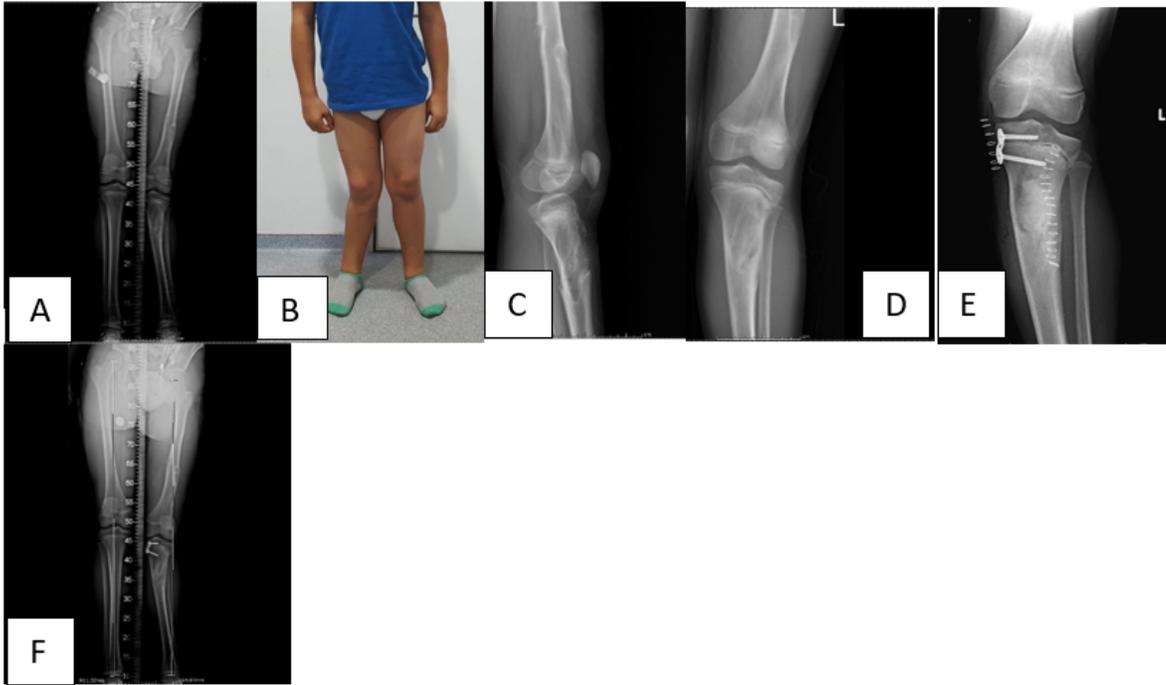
(A) Deformity and limb length discrepancy due to multiple enchondromatosis. (B) Clinical deformity. (C) Lateral x-ray. (D) AP x-ray. (E) Curettage and eight-plate epiphysiodesis. (F) Orthoroentgenogram after 6 months.
